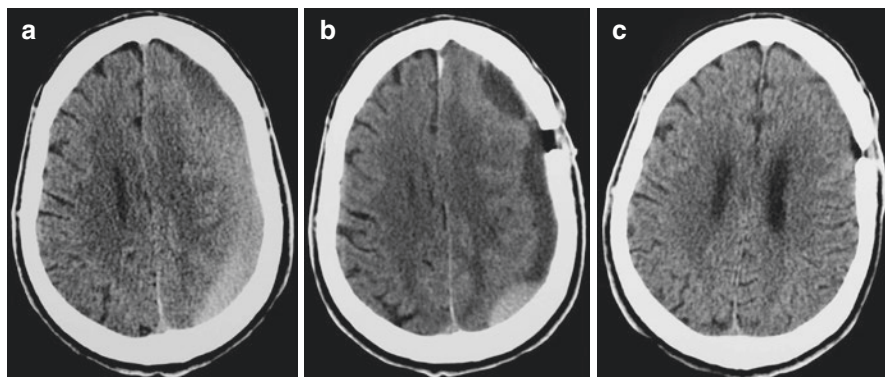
Initial preoperative CT scan (a), at 1 week postoperatively (b), and 3 months later (c) showing a residual collection into the subdural space (b) in an asymptomatic patient treated conservatively. Complete disappearance of the SDH at the third month control
